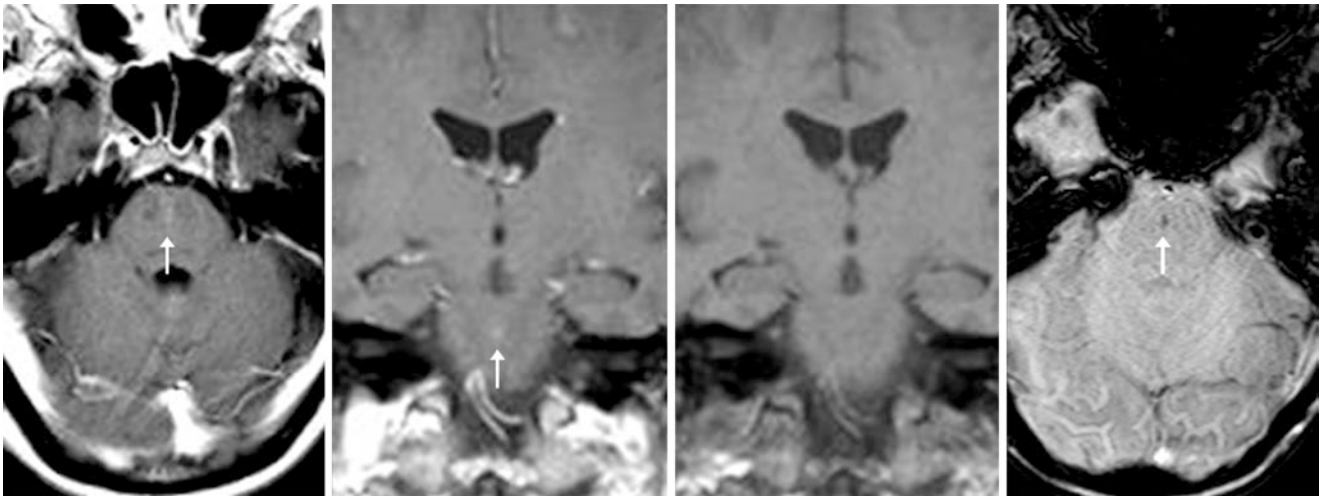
A 51 year old with a seizure was found to have faint enhancement within a small pontine BCT (arrows) on 1.5T MRI postcontrast axial (left) and coronal (left middle) T1WIs, which was invisible on noncontrast T1WI (right middle). SWI depicts an associated faint puff of dark signal on SWI (right)
